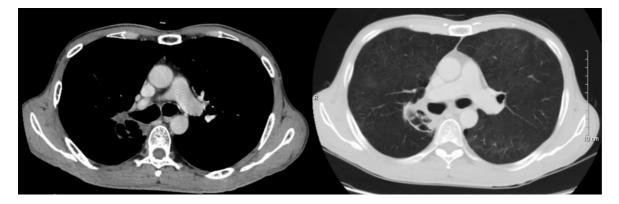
CT chest image after CRT
